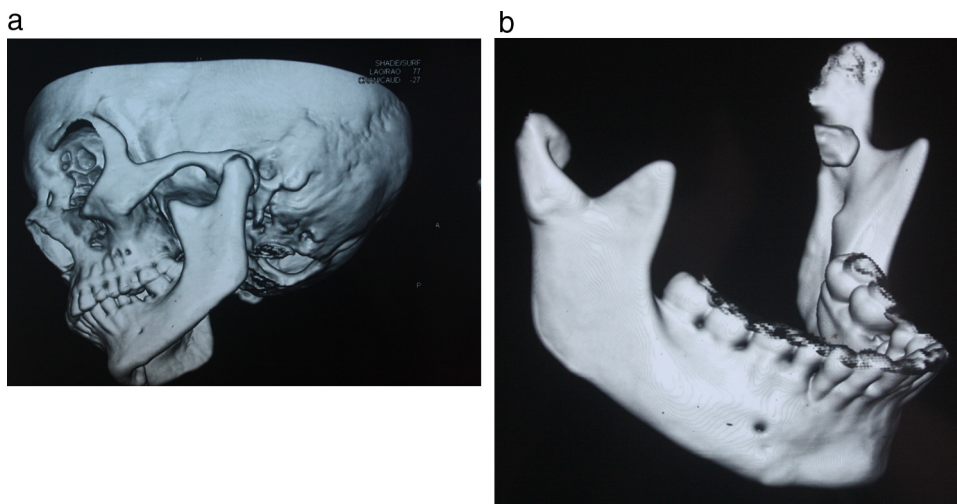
a and b: 3 D CT showing ankylotic mass left side and the displaced medial segment, please note the irregular surface of left condyle.
